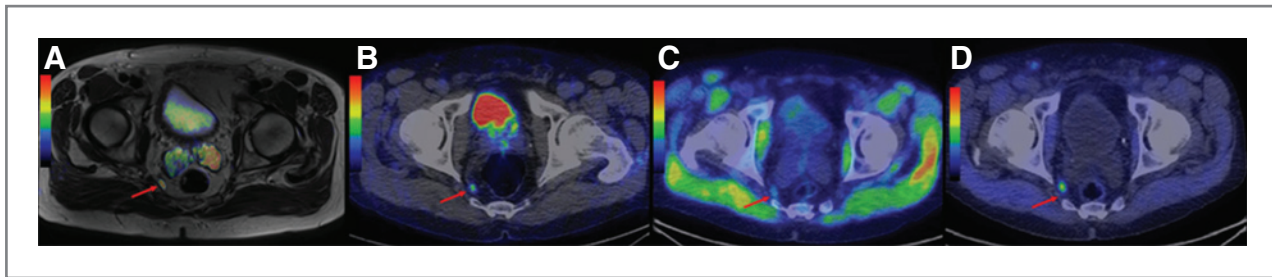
Preoperative fusion of diffusion-weighted imaging ($b = 750 \text{ s/mm}^2$) with T2-weighted MRI (A), BAY86-7548 PET/CT (B), and [¹¹C]-acetate PET/CT (C) showed suspicious presacral metastatic lymph node in patient no. 11. BAY86-7548 SUV_{max} of the node was 2.0. Unfortunately, the node could not be accessed during robotic prostatectomy and remained positive on postsurgical [¹¹C]-acetate PET/CT (D) as did the patient's PSA (1.9). The preoperative [¹¹C]-acetate SUV_{max} of the suspicious node was 2.5, whereas postsurgical was 6.2. Subsequently endocrine therapy was started. Please note that uptake of [¹¹C]-acetate in pelvic muscles is not seen in BAY86-7548 PET/CT images. BAY86-7548 image is scaled to SUV, with a minimum at 0 and maximum at 5, whereas [¹¹C]-acetate images (C) and (D) are scaled to SUV, with a minimum at 0, 0 and maximum at 3.6, 10.9, respectively.
